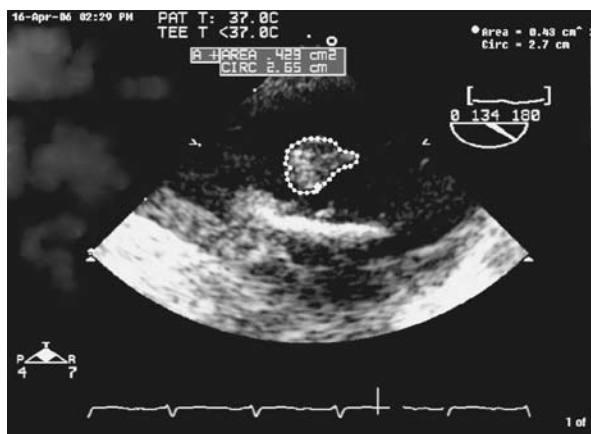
The transesophageal echocardiography demonstrated 2 large pedunculated vegetations on the mitral valve prosthesis with abscess in the posterior mitral suture ring with no paravalvular leak seen.
